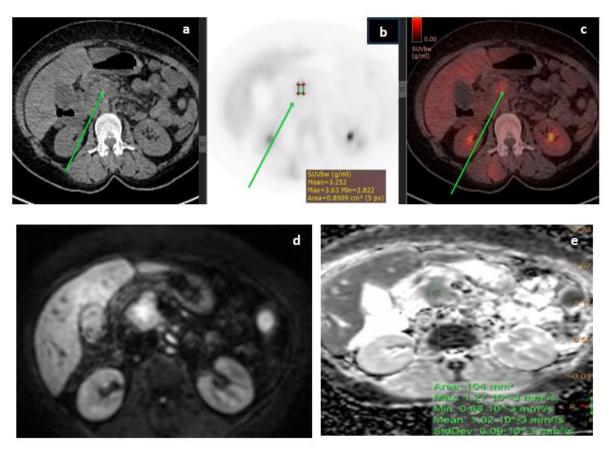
[a] CT axial cuts of pancreas showing pancreatic head and uncinate process lesion. [b] FDG-PET MIP axial image of pancreas showing low grade metabolic activity corresponding to pancreatic head and uncinate process lesion with SUVmax 3.5. [c] Fused PET-CT axial image at the level of pancreas showing mild metabolic activity of the visualized pancreatic head and uncinate process lesion. [d] DWI axial cuts of pancreas showing pancreatic head and uncinate process lesion, seen eliciting high signal on DWI. [e] ADC axial cuts showing pancreatic head and uncinate process lesion eliciting low signal on ADC with ADC mean value of 1.0x10⁻³.
